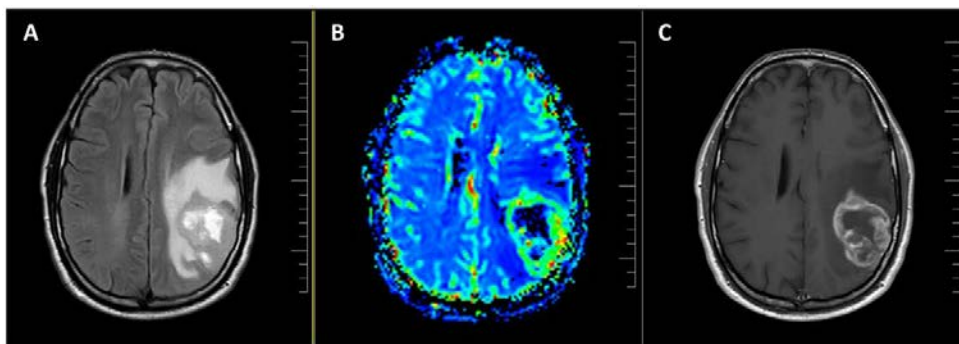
MRI sequences for glioblastoma detection. A, axial MRI FLAIR sequence demonstrates an extensive diffuse and infiltrative mass located in the left temporoparietal lobe. B, rCBV map shows an elevated rCBV in the periphery of the tumor (in green). C, axial MRI T1Gd sequence shows a heterogeneous irregular peripheral enhancement associated with the left temporoparietal lobe mass with non-enhancing central areas, formed by necrosis and hemorrhagic components. These images are from the Unit of Neuro-Oncology (Hospital Universitari de Bellvitge-ICO Duran I Reynals, Barcelona, Spain).
